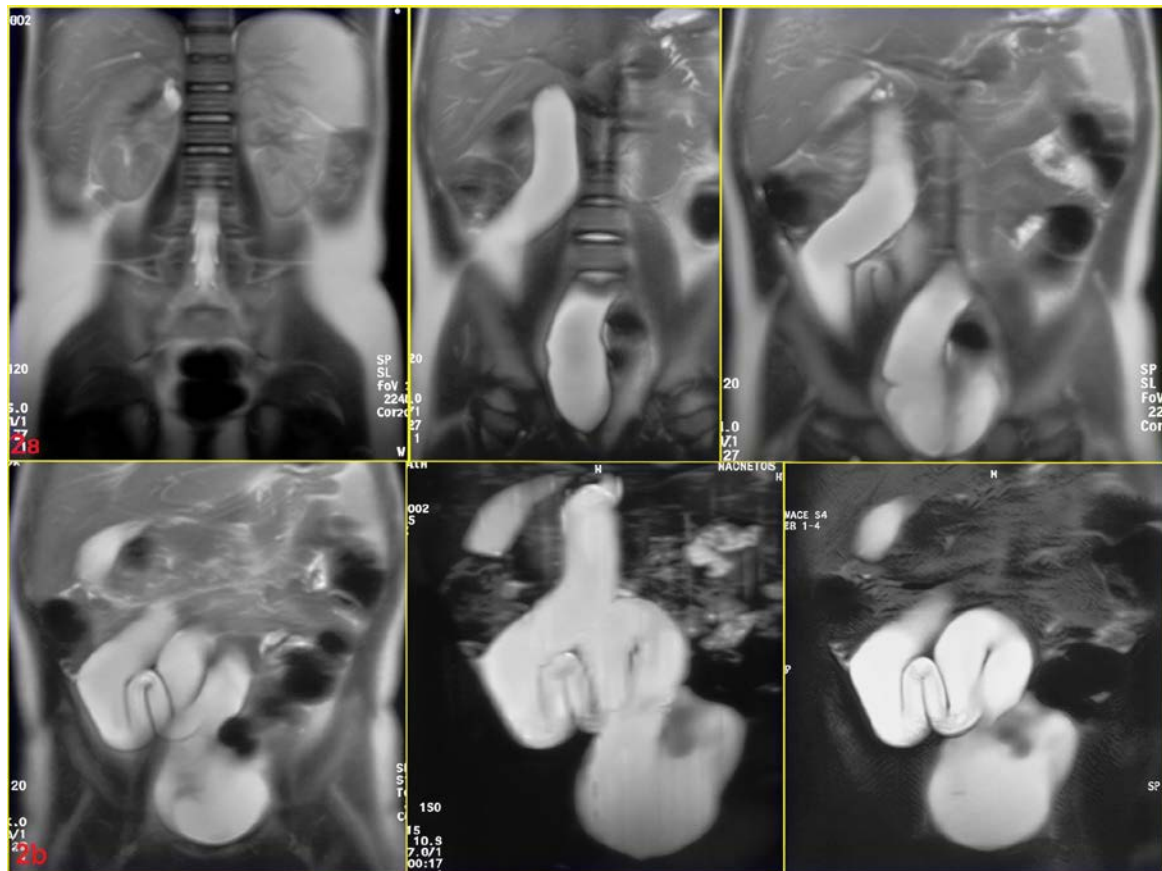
a-b Coronal T2-weighted images which show the extension of the dilated mesonephric duct. The right kidney was normal in the orthotopic position
